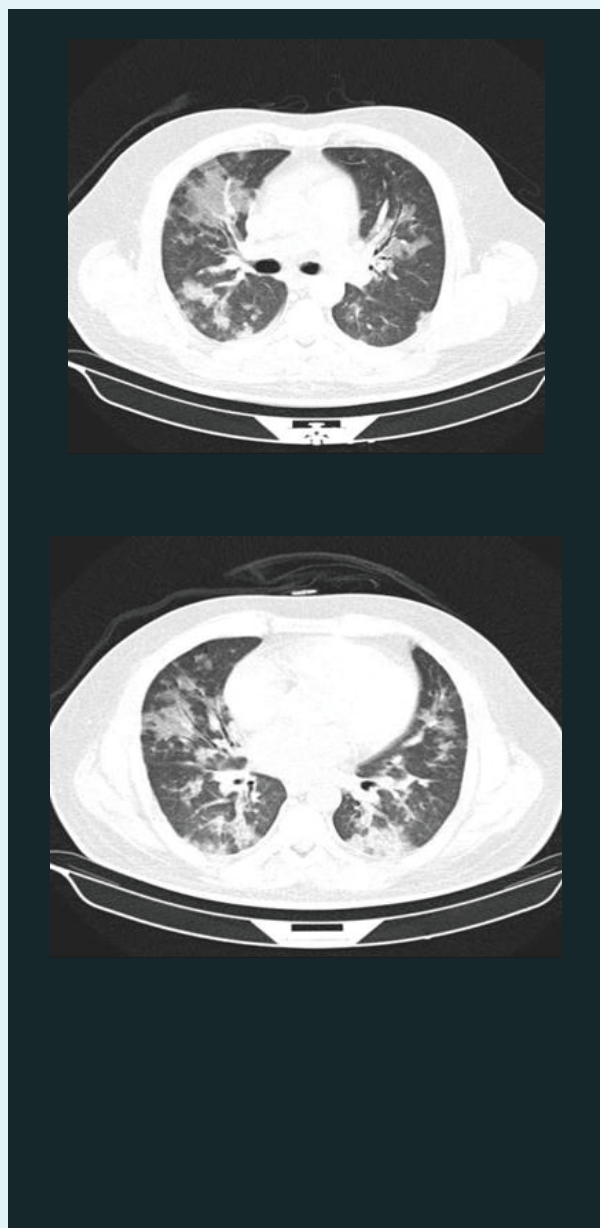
CT thorax on day 5 of admission: multiple condensation / matt glass areas with peribronchovascular distribution and peribronchovascular nodular formations with confluence tendency.
